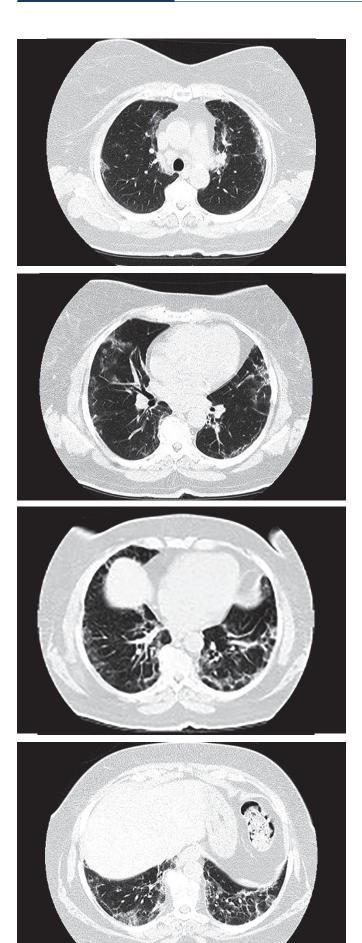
Chest CT after 14 days showing interlobular septal thickening and partial resolution of condensation.
